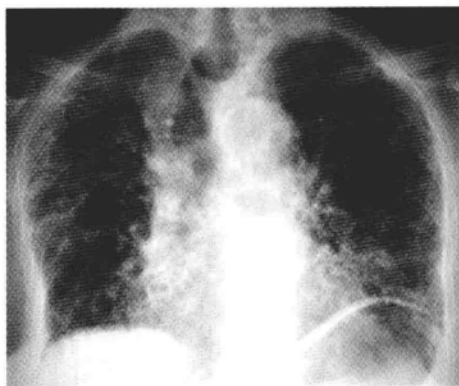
Diffuse reticular lung disease. Chest radiograph in a 94-year-old patient with diffuse reticular opacities due to idiopathic pulmonary fibrosis with honeycombing and traction bronchiectases. The lung volumes are typically reduced by a decreased pulmonary compliance.
